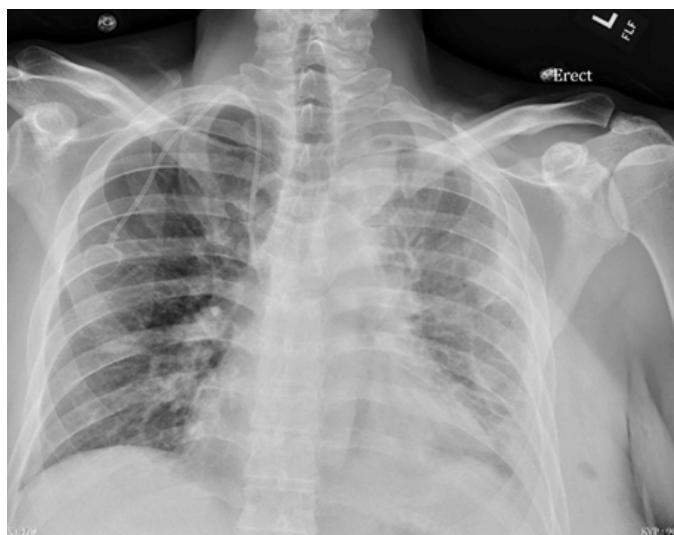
Chest X-ray on day 18: Mild cardiomegaly. There is mildly improved aeration of the lungs from prior exam and the diffuse left lung infiltrate appears mildly less prominent. Blunting of the left costophrenic angle suggesting a small left pleural effusion, without significant change. No pneumothorax identified. Interval removal of left chest tubes. There is a new right chest port with tip projecting over the superior vena cava.
